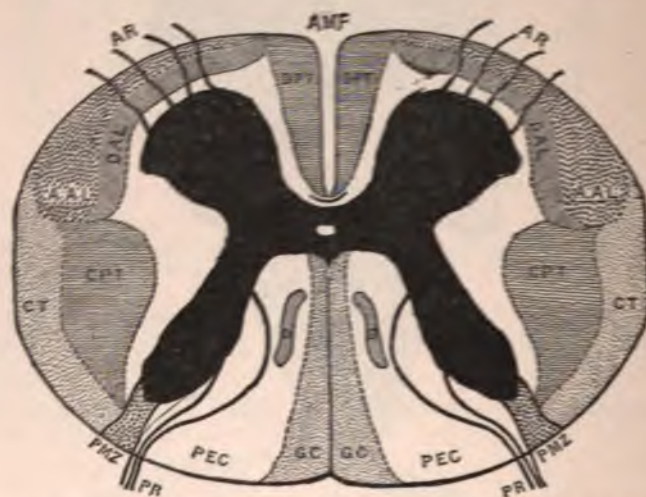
Scheme showing the Degeneration-Tracts, and the Paths that do not undergo Degeneration in the Cord. AMF, anterior median fissure; DPT and CPT, direct and crossed pyramidal tracts; AR and PR, anterior and posterior roots; AAL and DAL, ascending and descending antero-lateral tracts; CT, cerebellar tract; D, comma-shaped tract; PMZ, posterior marginal zone; PEC, postero-external column. The parts left white do not undergo degeneration. (Stirling.)
